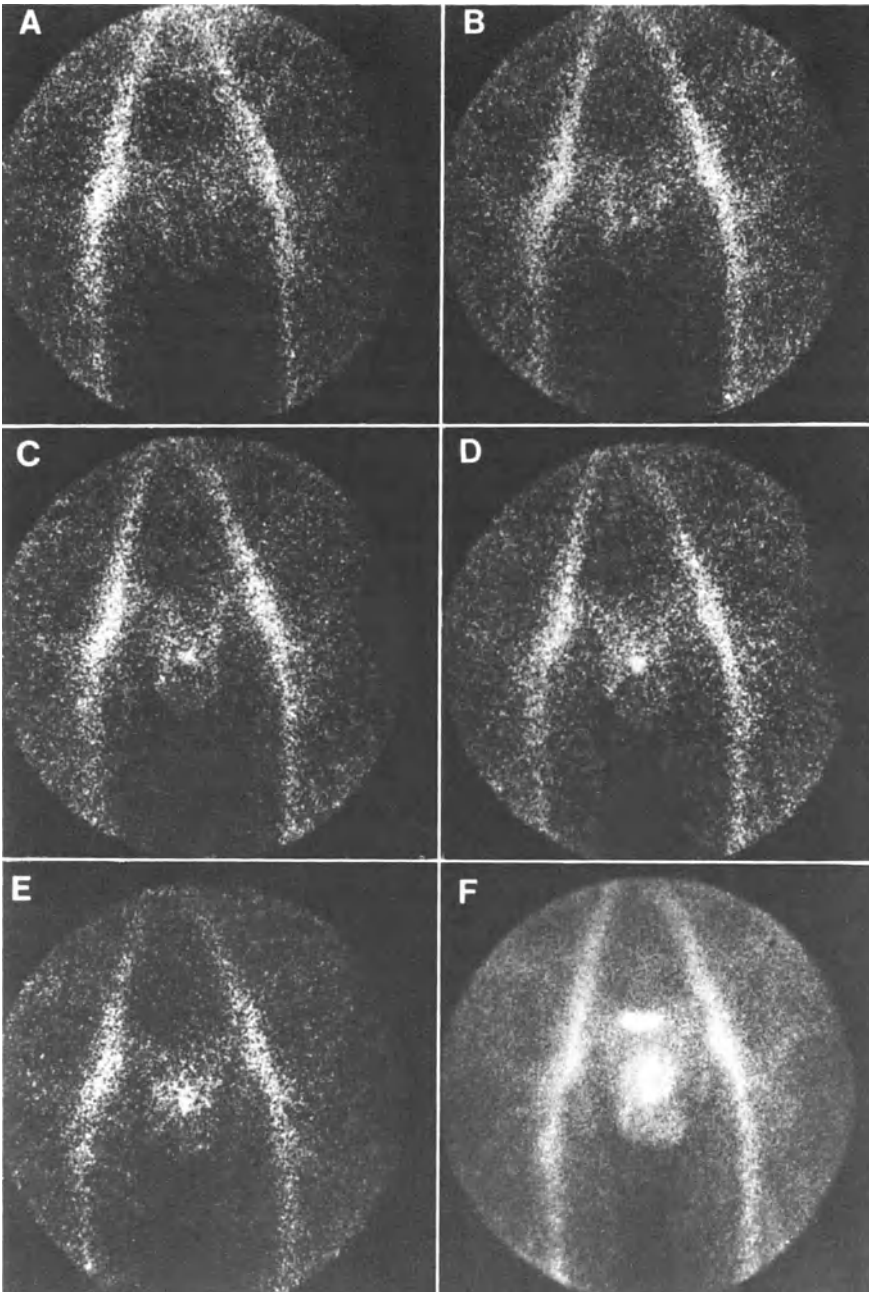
Normal scrotal scintigrams. A–D are early images; E is an image made during Valsalva's manoeuvre; F is an image made after equilibration of tracer
